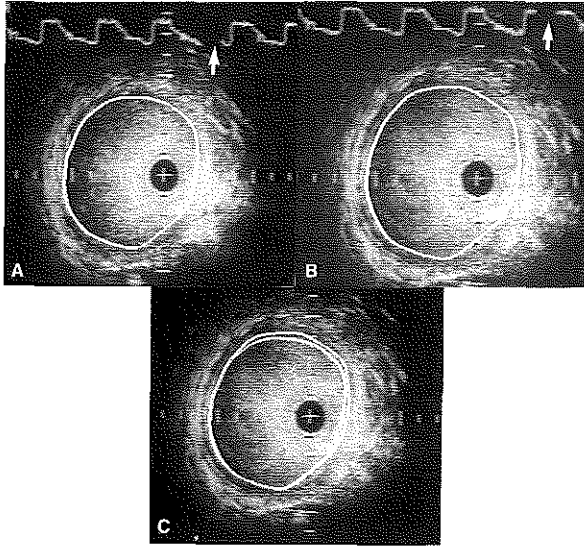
Intravascular ultrasound cross sections obtained in the common iliac artery at the same level. Contour detection was used to determine the change in lumen area at end-diastole (A) and systole (B), triggered by pressure data (arrow). (C) Both contours were plotted on the same cross section to visualize the difference.
